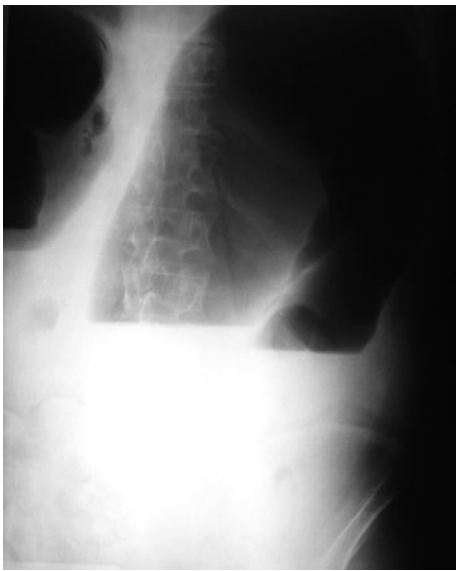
Plain erect abdominal X-ray film of sigmoid volvulus (dilated omega-like sigmoid colon)
